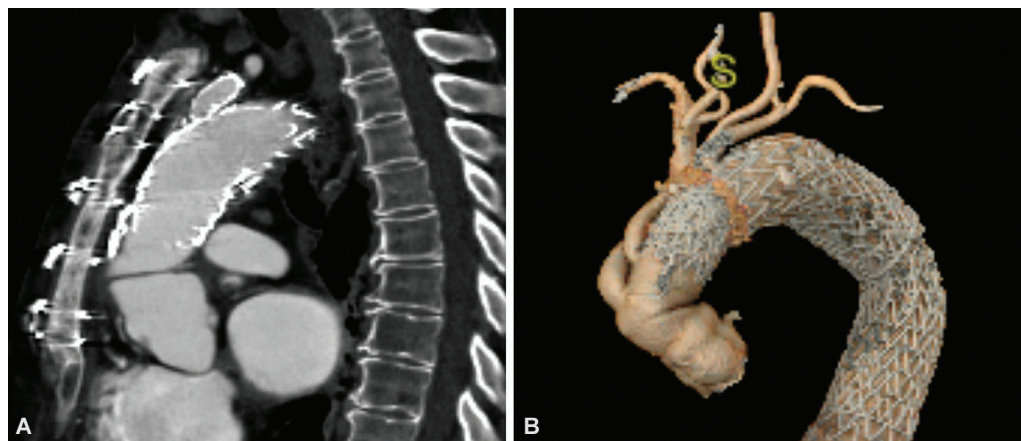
Patient who underwent zone 2 arch replacement with subsequent single-branched arch endograft: sagittal CT imaging (A) and 3D CT reconstruction (B). The side branch was used to stent the LSA, obviating the need for cervical transposition or bypass. Note the proximal debranching of the IA and LCCA, thus creating an appropriate landing zone for the TEVAR. CT, computed tomography; LCCA, left common carotid artery; LSA, left subclavian artery; TEVAR, thoracic endovascular aortic repair.
